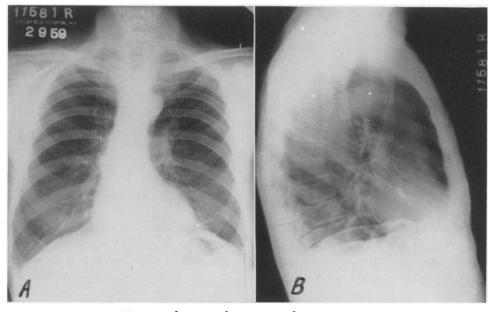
Admission chest x-rays of patient D. P.
